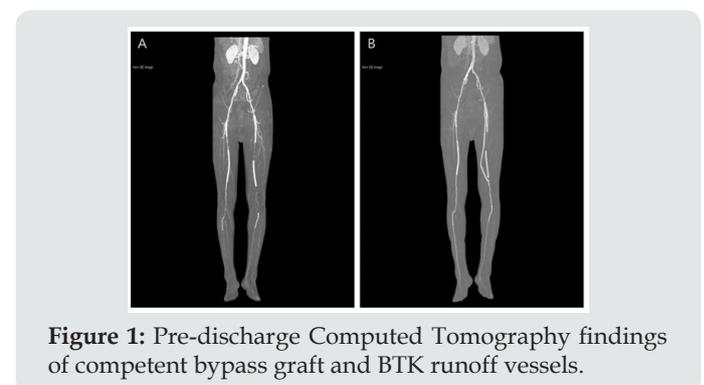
Pre-discharge Computed Tomography findings of competent bypass graft and BTK runoff vessels.
